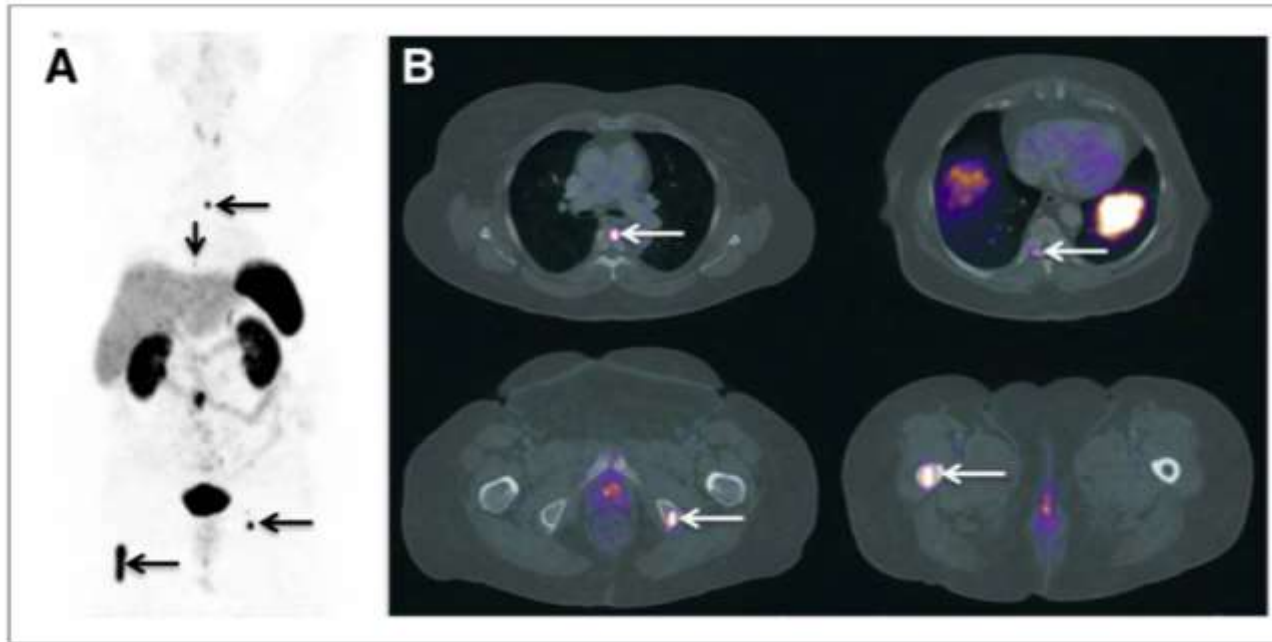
Upstaging of patient with history of small intestine NEN and 6.5-cm lesion within right proximal femur with benign appearance at prior MRI. (A) DOTATATE maximum-intensity-projection image revealed multiple mesenteric and pelvic, as well as multiple unexpected osseous, metastases (arrows). (B) On axial PET/CT, the unexpected soft-tissue and bone metastases were detected in more detail (arrows). Intended treatment was converted from surgery and octreotide to surgery, octreotide, and selective radiotherapy of bone metastases. (Adapted from (66).)
